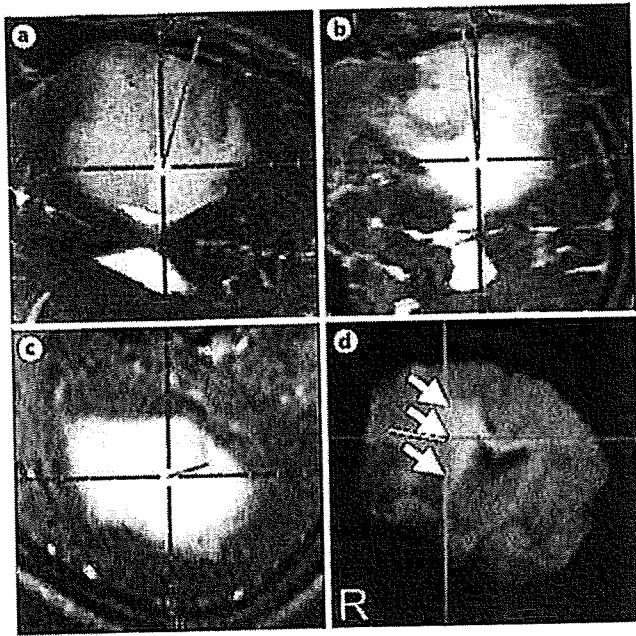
Navigation images based on intraoperative MR imaging of a 37-year-old female with an anaplastic astrocytoma when MEPs of the left lower extremity were obtained with a 7-mA stimulation current. T₂-weighted images with (a) axial section, (b) vertical section in the cranio-caudal direction and (c) horizontal section and (d) coronal DW images. The stimulation site directed by a crosshair cursor is displayed on the lateral boundary of the area (arrows) containing the pyramidal tract with a high signal on the DW images.
